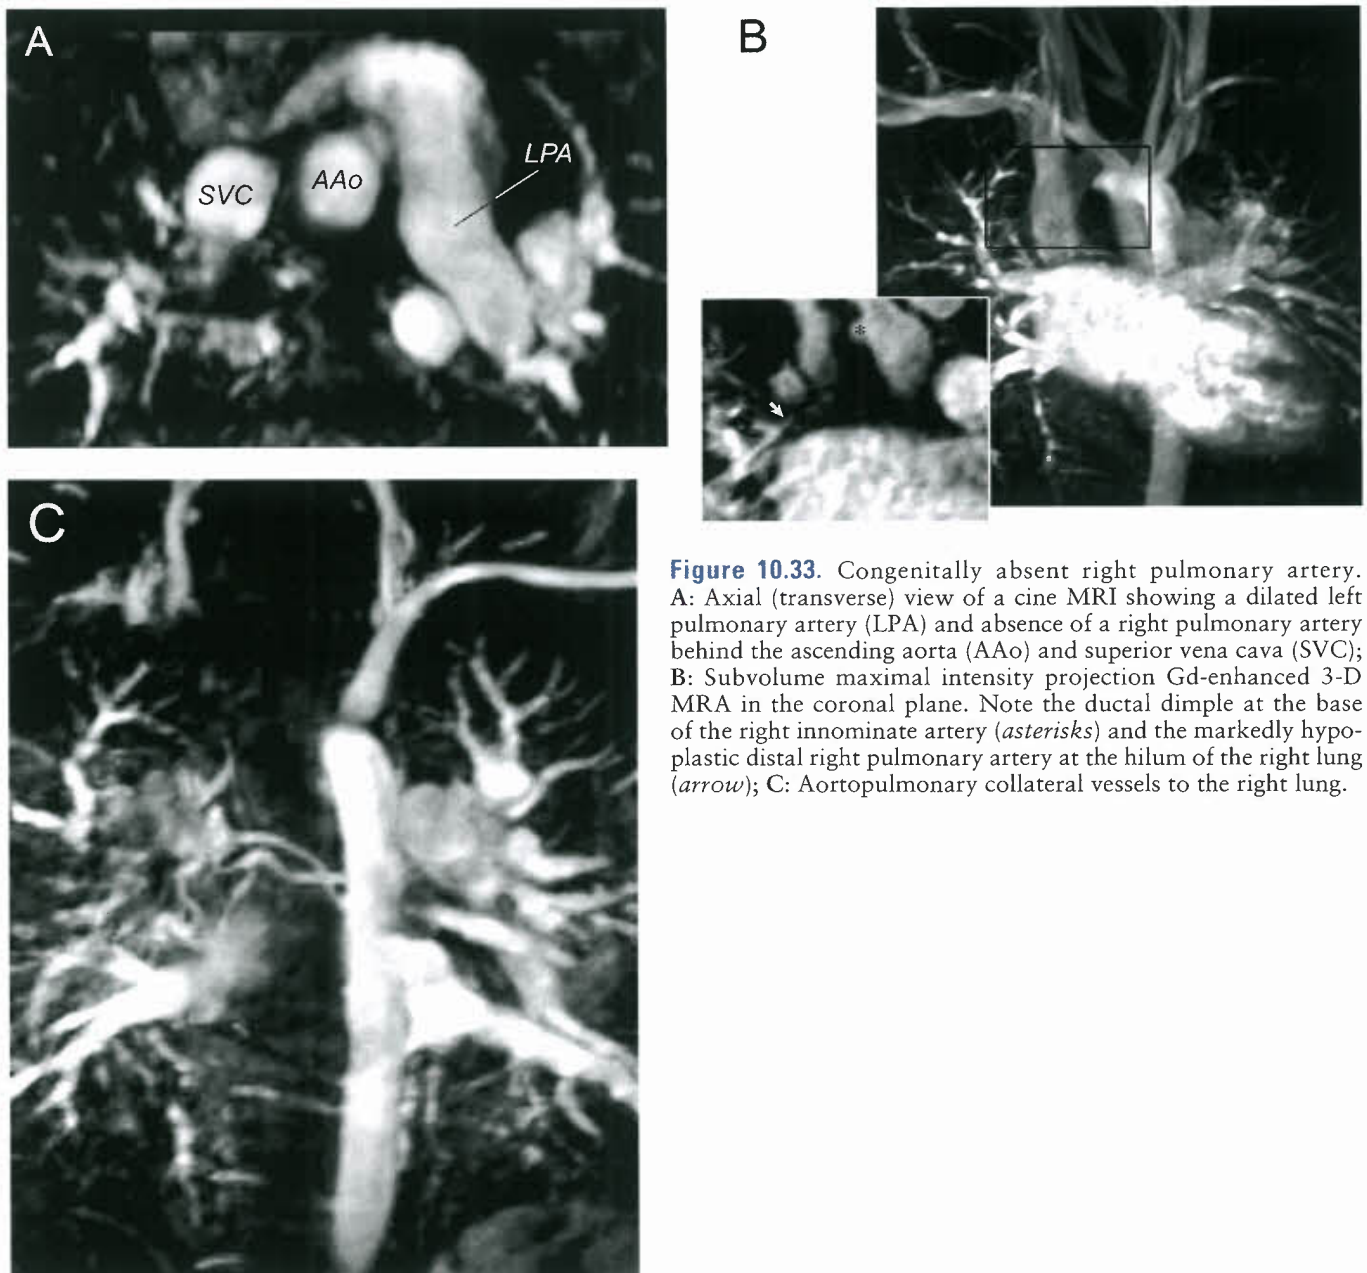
Congenitally absent right pulmonary artery. A: Axial (transverse) view of a cine MRI showing a dilated left pulmonary artery (LPA) and absence of a right pulmonary artery behind the ascending aorta (AAo) and superior vena cava (SVC); B: Subvolume maximal intensity projection Gd-enhanced 3-D MRA in the coronal plane. Note the ductal dimple at the base of the right innominate artery (*asterisks*) and the markedly hypoplastic distal right pulmonary artery at the hilum of the right lung (*arrow*); C: Aortopulmonary collateral vessels to the right lung.
